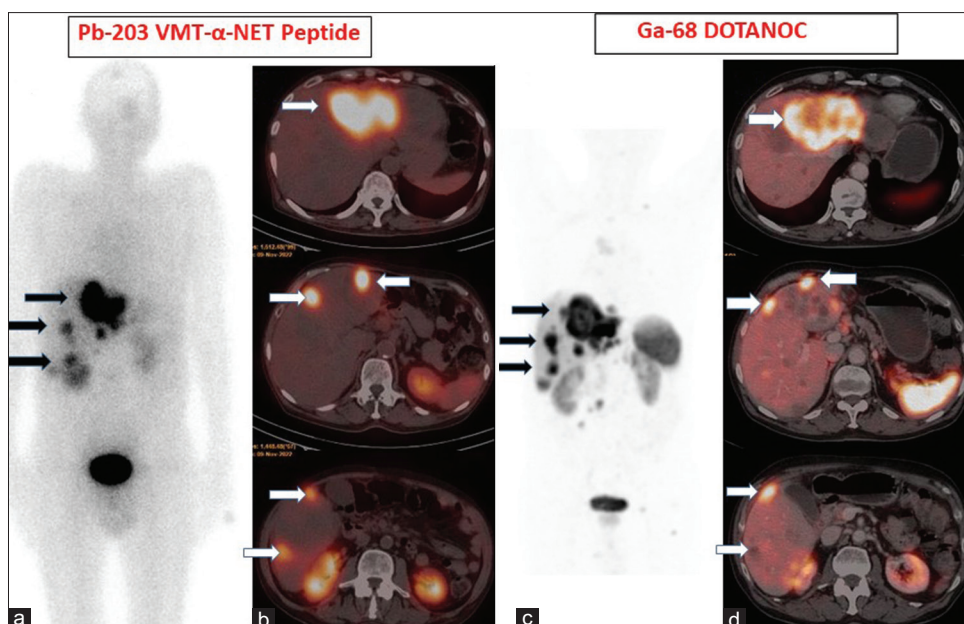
Whole body Planar (a) and transverse SPECT-CT (b) images acquired at 2 h postinjection of ^{203}Pb -VMT- α -NET showed excellent uptake of ^{203}Pb -VMT- α -NET peptide in the liver metastatic sites in a patient of metastatic NET. A comparison with ^{68}Ga -DOTANOC PET/CT scan demonstrated a similar distribution of the tracer in the metastatic liver lesions-Maximum intensity projection (c) and Fused transverse PET/CT slices (d). Solid arrows showing uptake of tracer at the sites of the hepatic metastases. Pb: Lead, NET: Neuroendocrine tumor, SPECT-CT Single-photon emission computed tomography-CT, PET: Positron emission tomography
